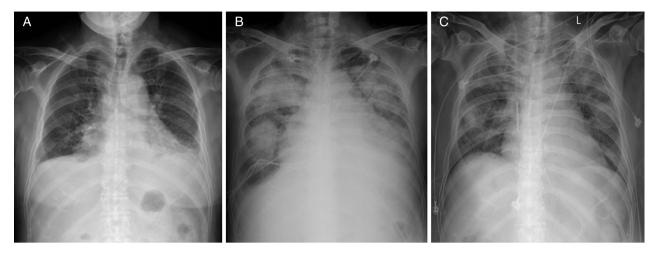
(A) The chest X-ray on admission showed cardiomegaly and increased bilateral lower infiltration. (B) The chest X-ray before intubation revealed increased heart size and new bilateral patchy consolidation. (C) The chest X-ray on the day of general ward transferal showed resolution of bilateral patches and a right-sided double lumen catheter.
